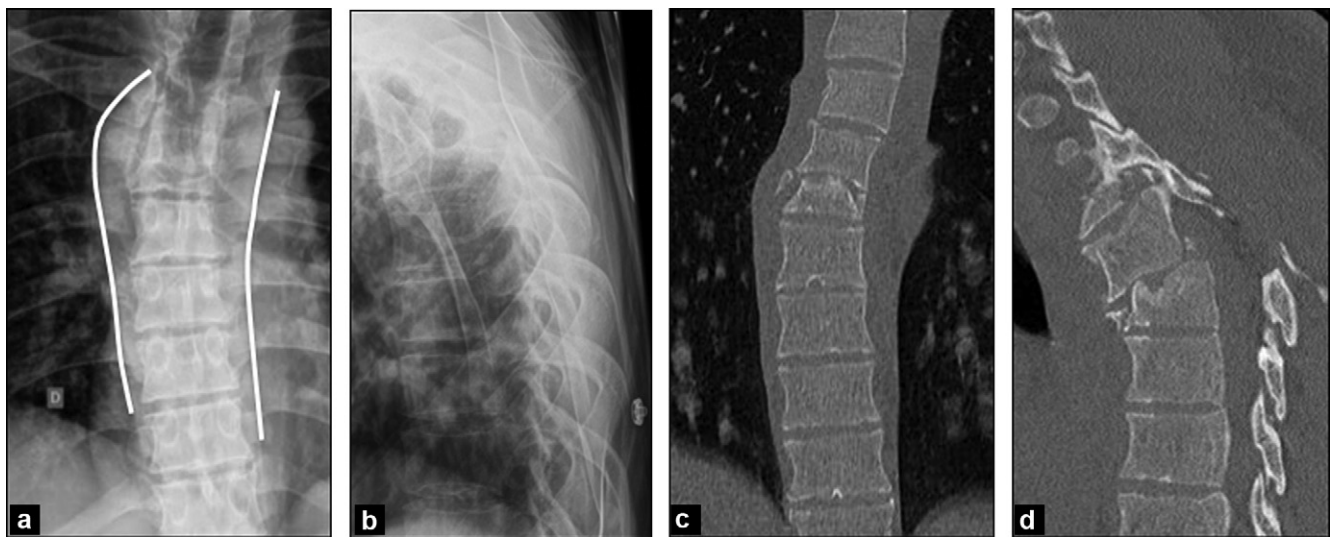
Trauma of the thoracic spine. a, b: the X-rays show a para-vertebral soft-tissues swelling; c, d: CT (coronal and sagittal) show a fracture-dislocation T4-T5.
